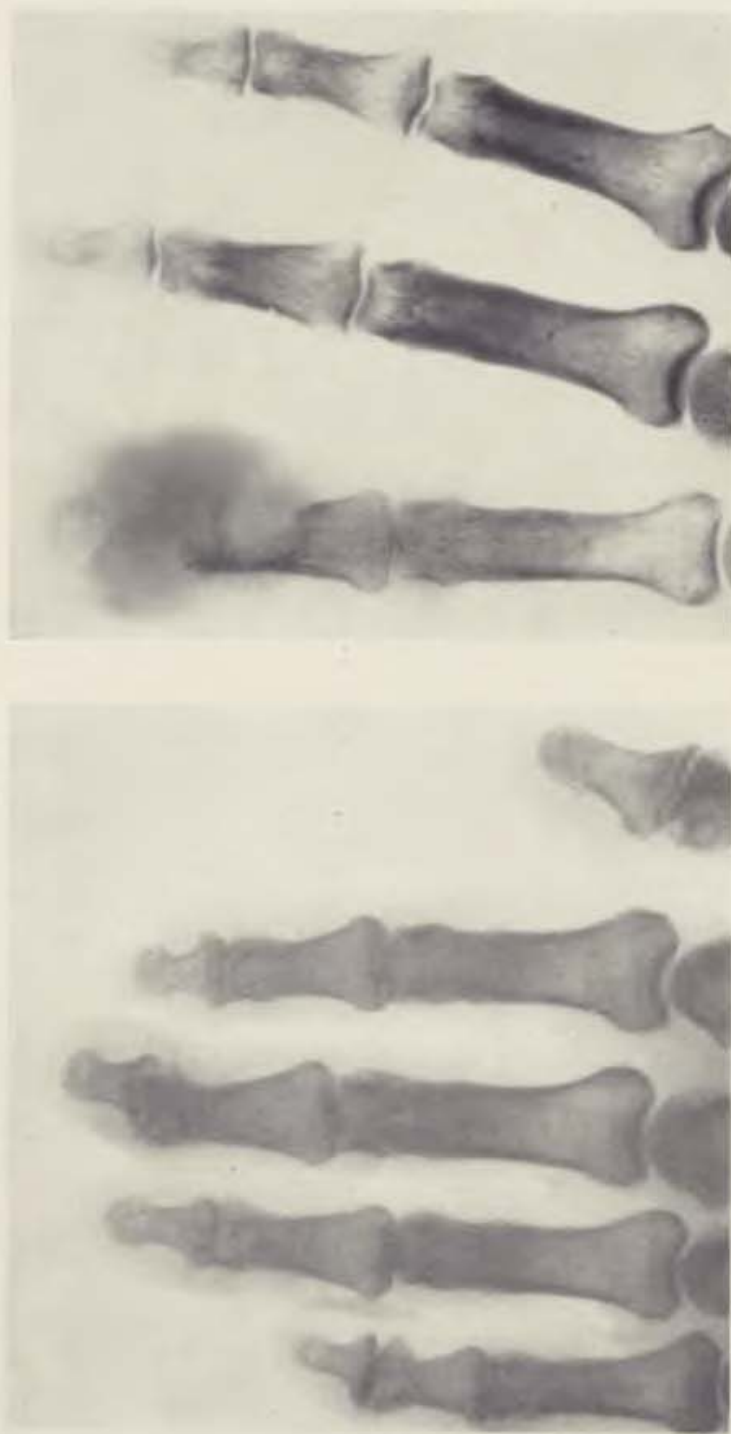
Marked destructive arthritis of the terminal interphalangeal joints of the II to V digits with subluxation in the III digit. The other rebuilding changes are still of a limited degree. — Fig. 5. Destruction of the terminal and middle phalanx of the little finger in a patient with spinocellular carcinoma in X-ray dermatitis following invasion of the tumour into the depth
